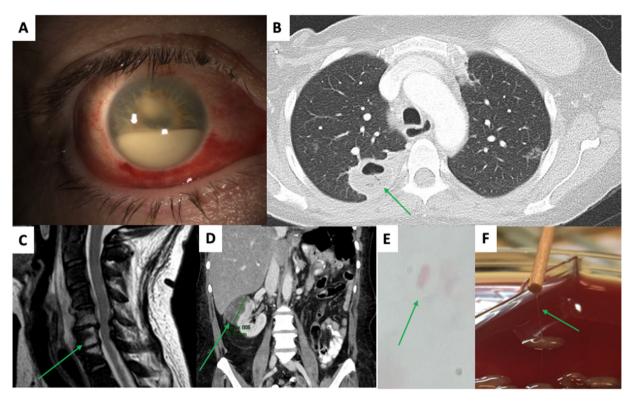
Clinical, microbiological, and radiographic findings of *K. Pneumoniae* infection. A, Right eye hypopyon. B, Chest CT demonstrating one of multiple lung abscesses. C, Cervical spine MRI demonstrating osteomyelitis. D, Abdominal CT demonstrating perinephric abscess. E, Encapsulated gram negative rod. F, Positive string test.
